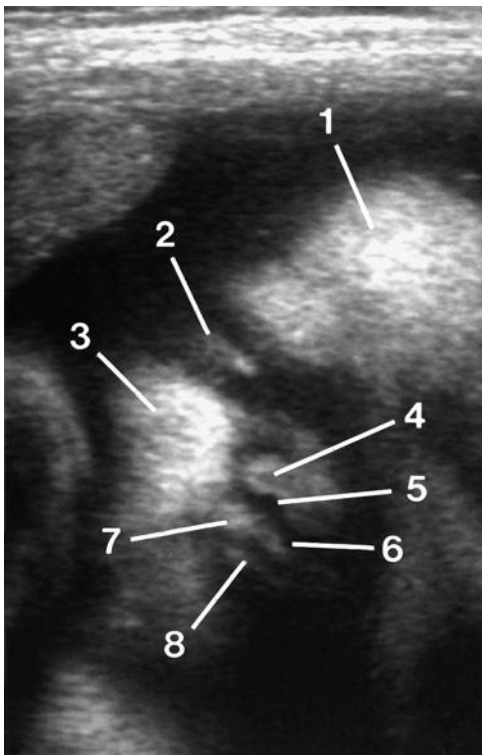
Sonogram of the fetal face. Even though this image is a tomogram with relatively little depth, facial features are seen well. Amniotic fluid surrounding the face provides the “contrast” for visualization. 1, brow; 2, eyelid; 3, cheek; 4, ala of nose; 5, nostril; 6, philtrum; 7, upper lip; 8, lower lip.
